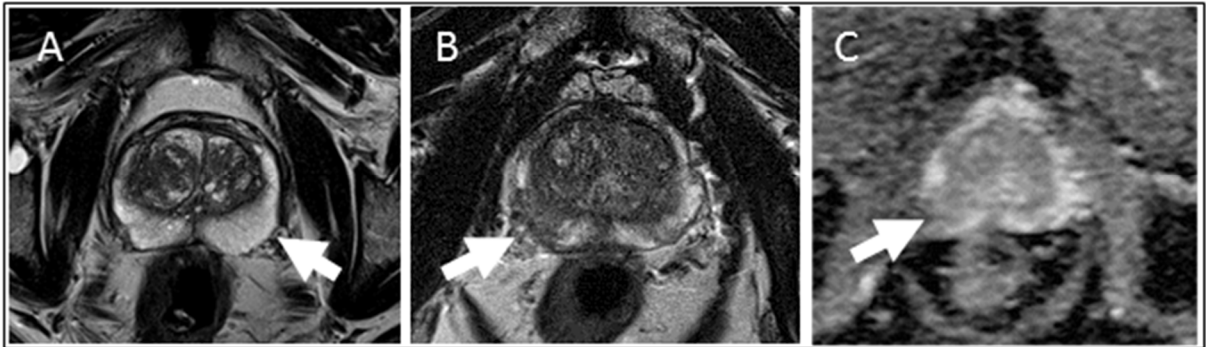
(A) Example of PI-RADS score of 1 T2-weighted image of a normal peripheral prostatic zone and central benign hyperplasia. (B/C) Example of a PI-RADS score 2 lesion. (B) Stripy bilateral changes in peripheral zone on the T2-weighted image. (C) The apparent diffusion coefficient (ADC-map) shows a mild diffusion restriction in analogy to the finding on the T2-weighted image.
